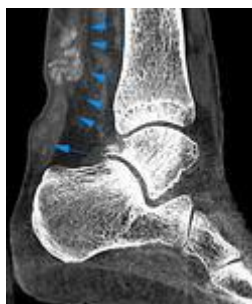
CBCT-image of the wright ankle with the presence of the podagric tofuses during...
